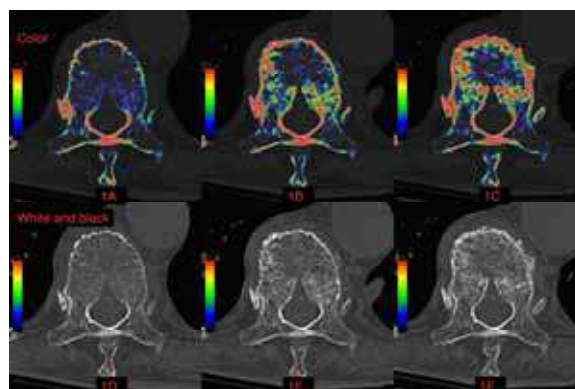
CT color mapping images (A: at the time of injury; B: 4 weeks after injury; C: 12 weeks after injury), and conventional CT images (D: at the time of injury; E: 4 weeks after injury; F: 12 weeks after injury)
